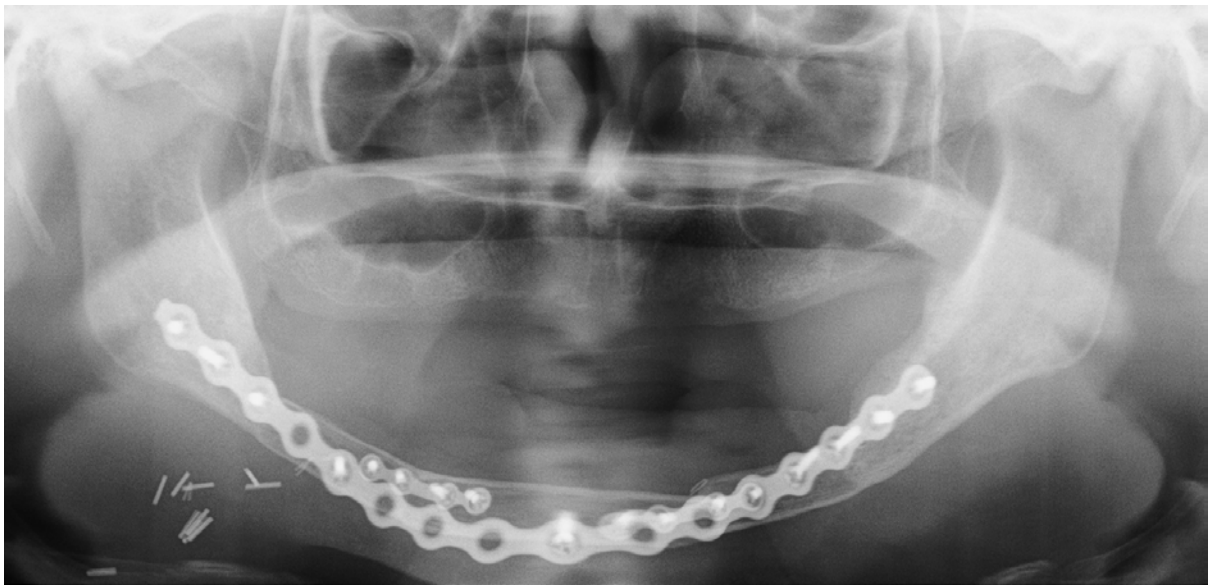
Panoramic radiographs of a 57-year-old woman with mandibular ameloblastoma. Fixation hardware was removed and vestibuloplasty performed for denture placement at 1.1 postoperative years. *A*, Initial radiograph at 9 postoperative days showing fibula bone height of 13.3 mm in the body segment. *B*, Follow-up radiograph at 1 postoperative year showing fibula bone atrophy of 17% in the body segment. *C*, Late follow-up radiograph at 3.7 postoperative years showing fibula bone atrophy of 49% in the body segment.
